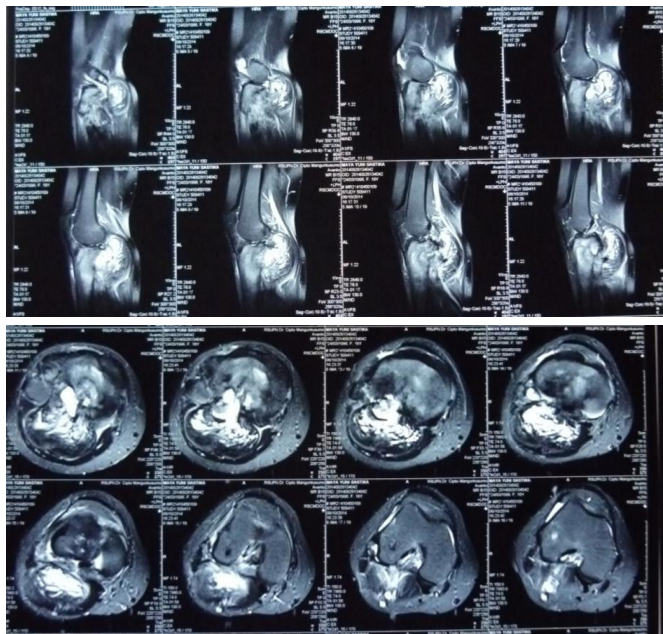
MRI of the Right Knee Suggestive a Malignant Tumor
